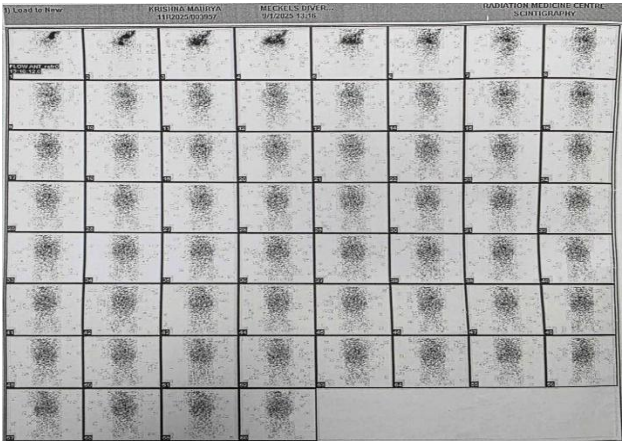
Meckel's scan - anterior planar scintigraphy view (01 September 2026)- shows focal tracer uptake in RIF, suggestive of ectopic gastric mucosa in the RIF region likely to represent Meckel's diverticulum.
